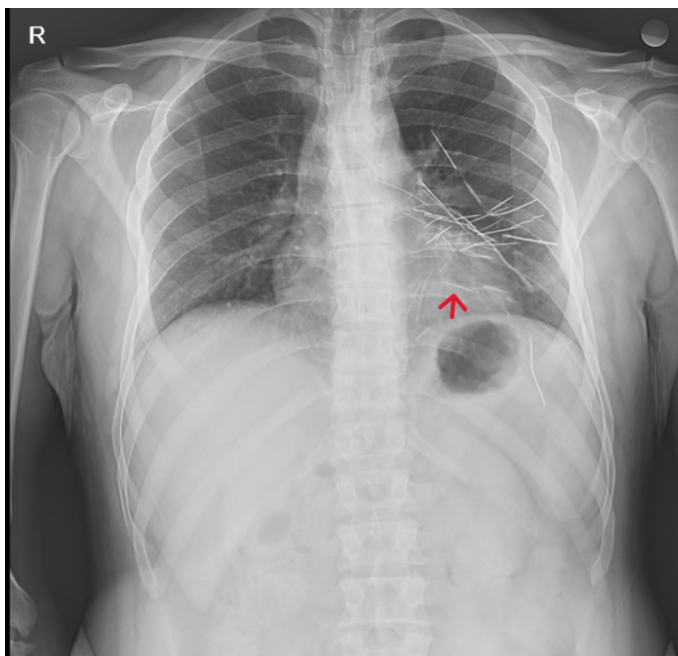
Chest radiograph showing multiple linear metallic foreign bodies over the cardiac silhouette.
